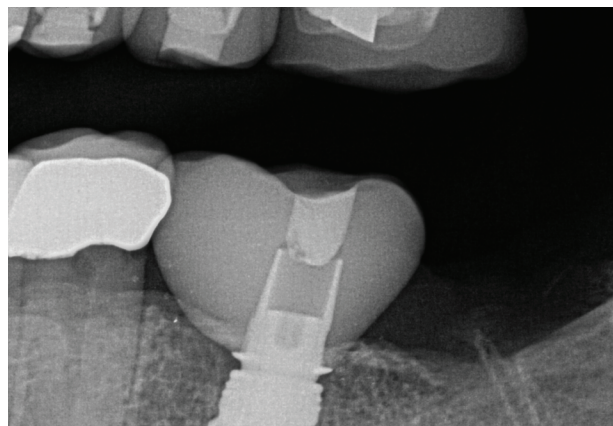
Two-month postoperative bitewing
